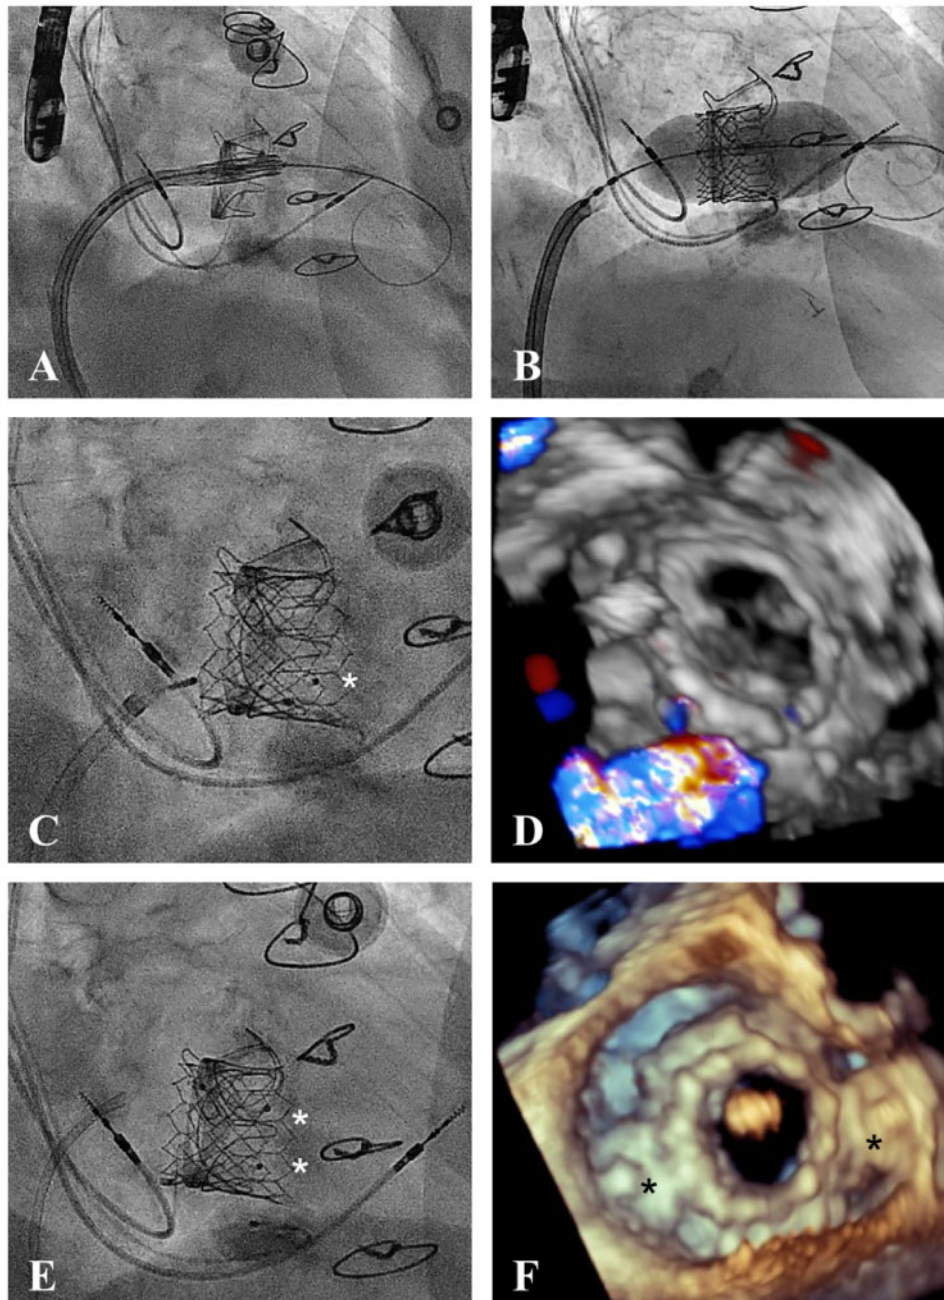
Procedure. (A) Positioning of the valve into the degenerated surgical bioprosthesis. (B) Implantation of a 26 mm balloon-expandable valve. (C) Occlusion the medial paravalvular leak (10/5 mm Amplatzer Vascular Plug III; asterisk). (D) Three-dimensional Doppler atrial view showing the result after implantation of the first plug and the remaining wide lateral jet. (E) Closure of the lateral paravalvular leak (8/4 mm Amplatzer Vascular Plug III; second asterisk). (F) Three-dimensional transoesophageal echocardiography view showing the final result after valve-in-valve implantation and implantation of two plugs (asterisks).
